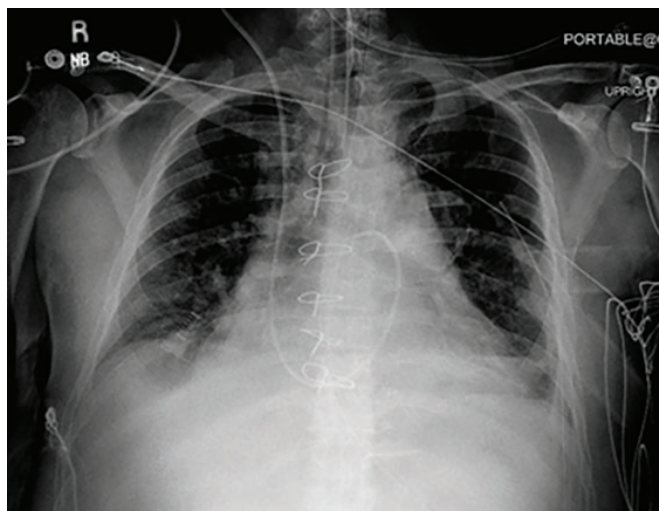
Radiography immediately after surgery showed cardiac tamponade, which led to repeat sternotomy with mediastinal washout.
